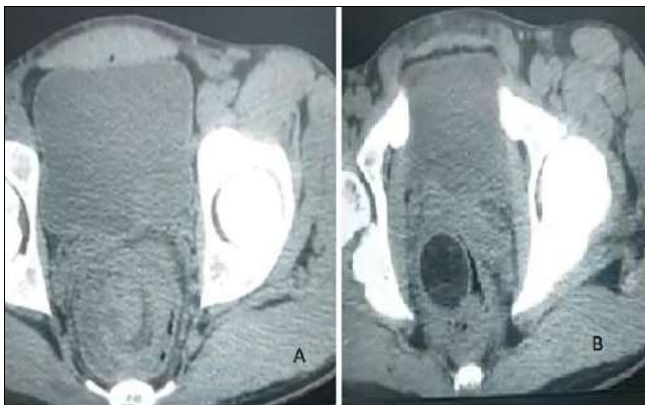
A: CT showing colocolic intussusception; B: CT showing the lipoma
